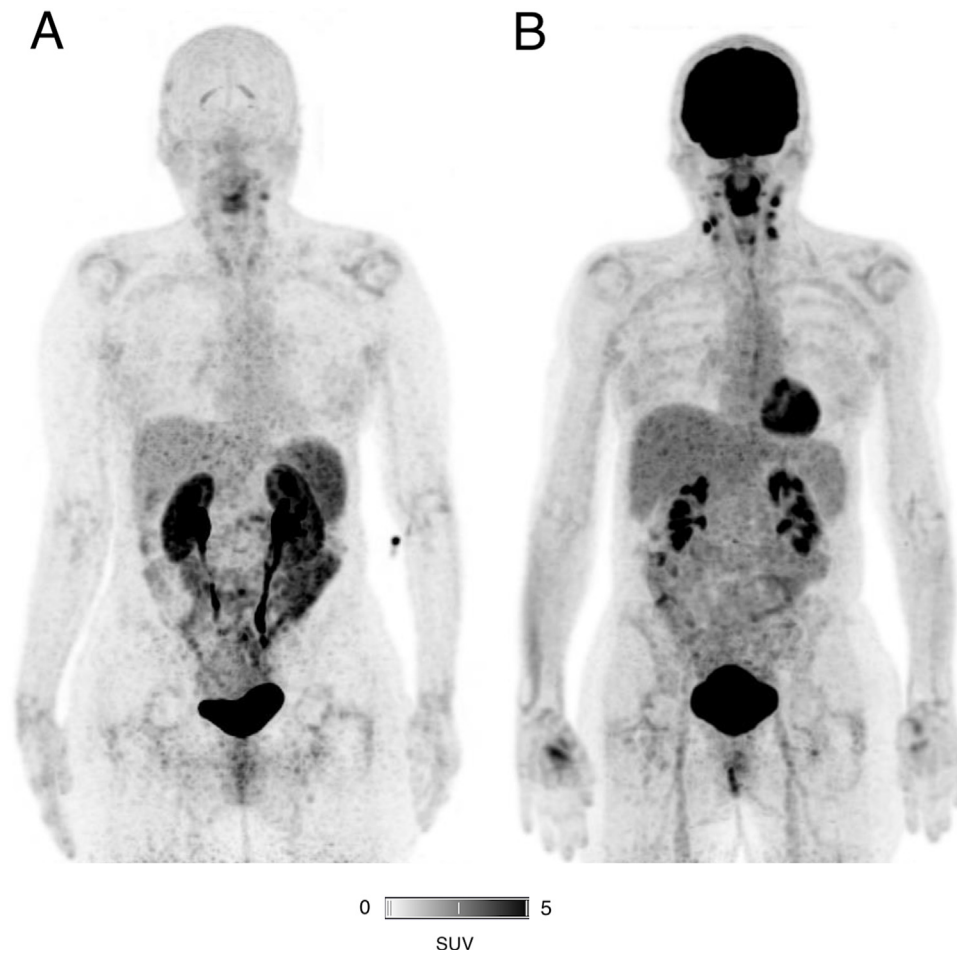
A. [^{68}Ga]Ga-NODAGA-RGDyK PET/CT maximum intensity projection (MIP) view. B. [^{18}F]FDG PET/CT MIP view.
